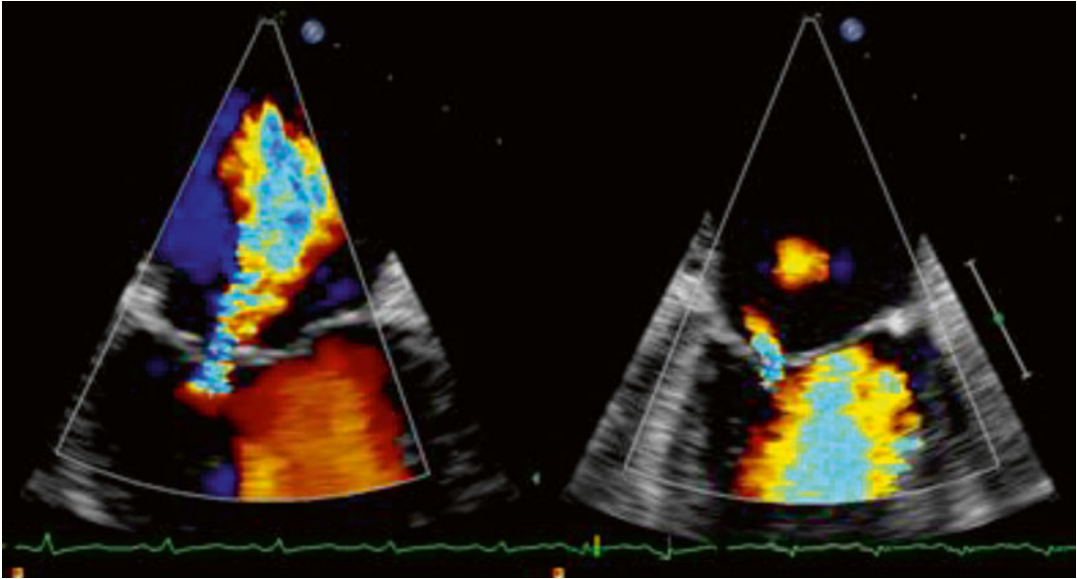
Transesophageal Echocardiogram with PISA measurement, pre- and post-implant
